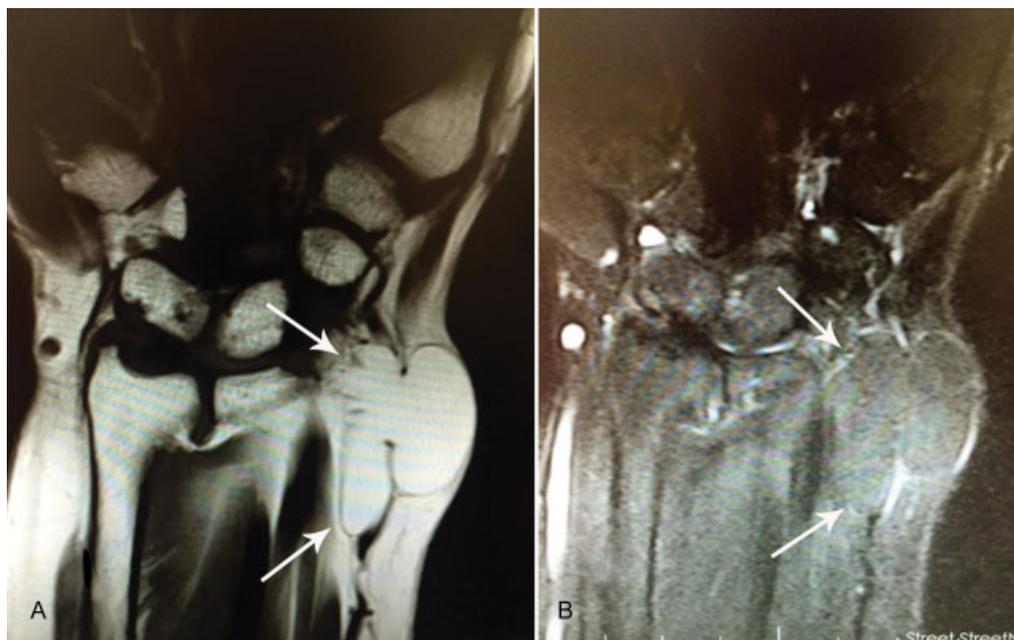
(A) Coronal T1-weighted and (B) coronal fat-suppressed T2-weighted images show a superficially located lipoma at the dorsal aspect of the wrist (arrows).
